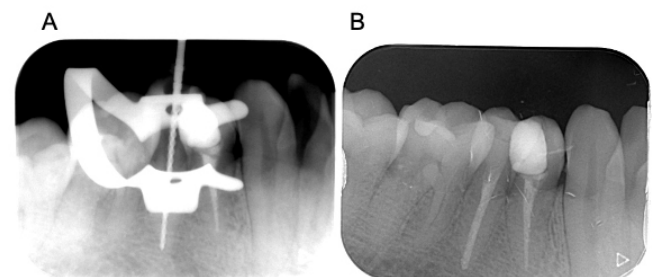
Periapical radiographs taken (A) during root canal treatment of the mandibular second premolar and (B) after root canal treatment.
